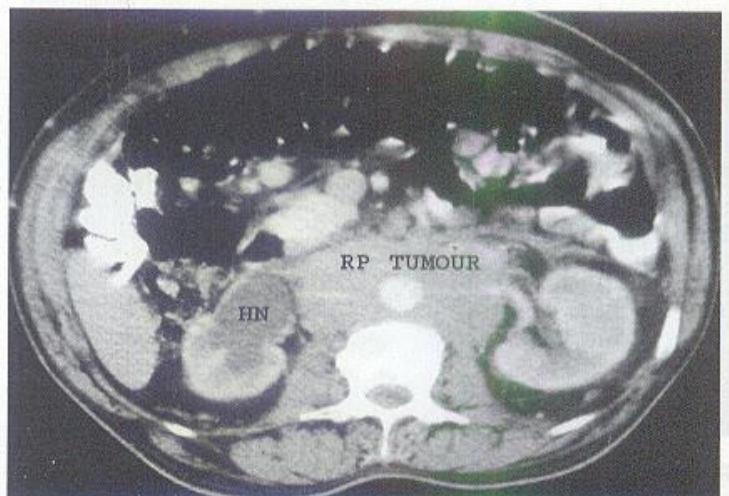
CT scan showing retroperitoneal tumour encasing the aorta with hydronephrosis of right kidney due to ureteral obstruction.
